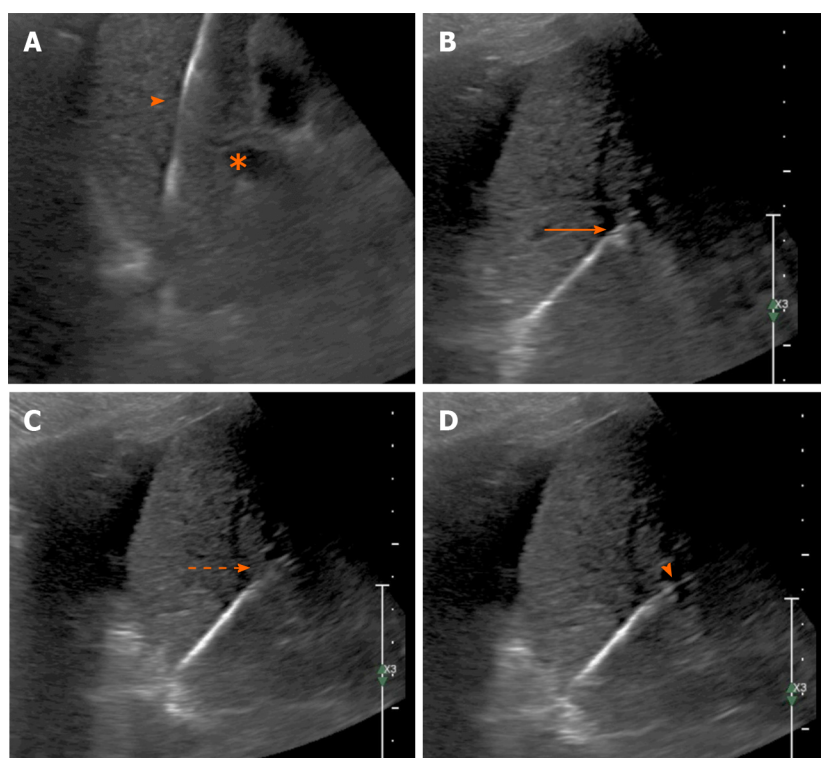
Ultrasound image. A: Gray scale ultrasound image showing the stiff guidewire in the right hepatic vein (arrowhead) with the right portal vein branch in the same image (asterisk); B: The needle-catheter combination advancing towards the portal vein branch (arrow); C: Indentation of the needle (arrow); D: The needle is seen entering the portal vein (arrowhead).
